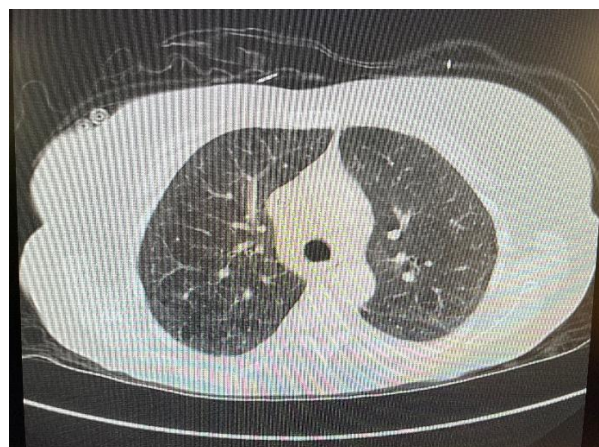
CT of the chest showing interstitial and ground glass changes. No pathologically enlarged lymph nodes.
